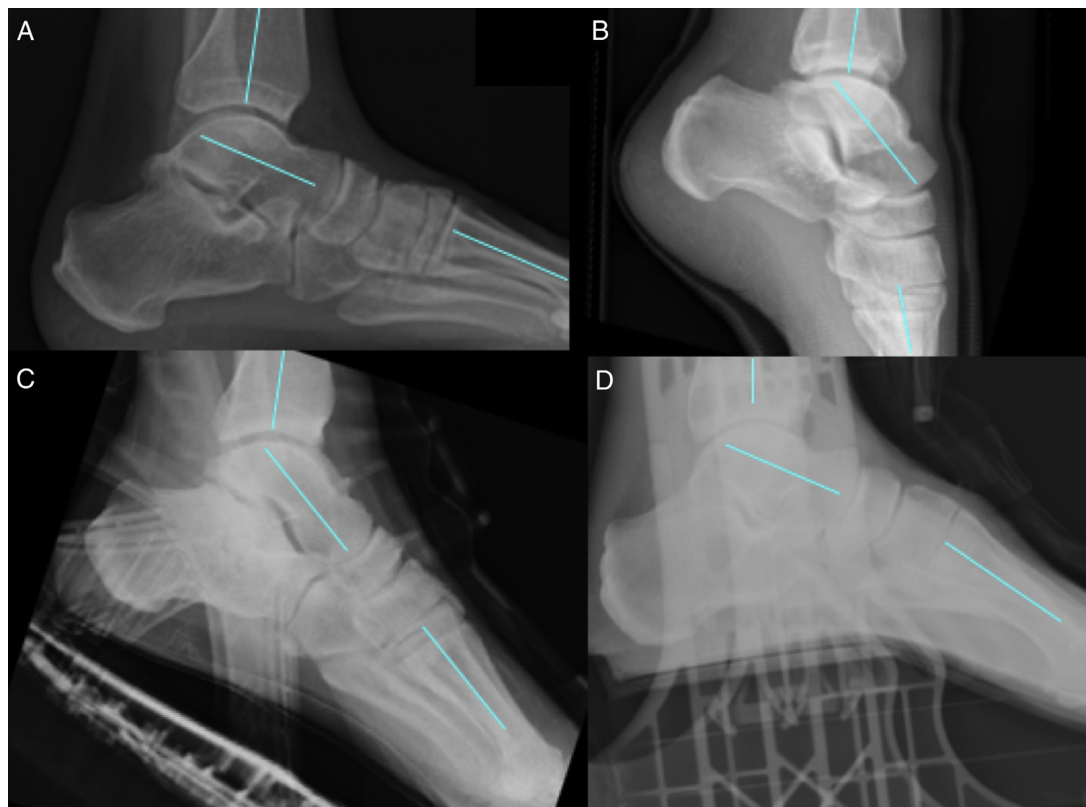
Lateral radiographs depicting (A) typical weightbearing stance (control), (B) non-weightbearing patient in an equinus cast, (C) weightbearing patient within the external equinus-corrected brace, and (D) weightbearing patient within the fixed angle walking boot with wedges.
